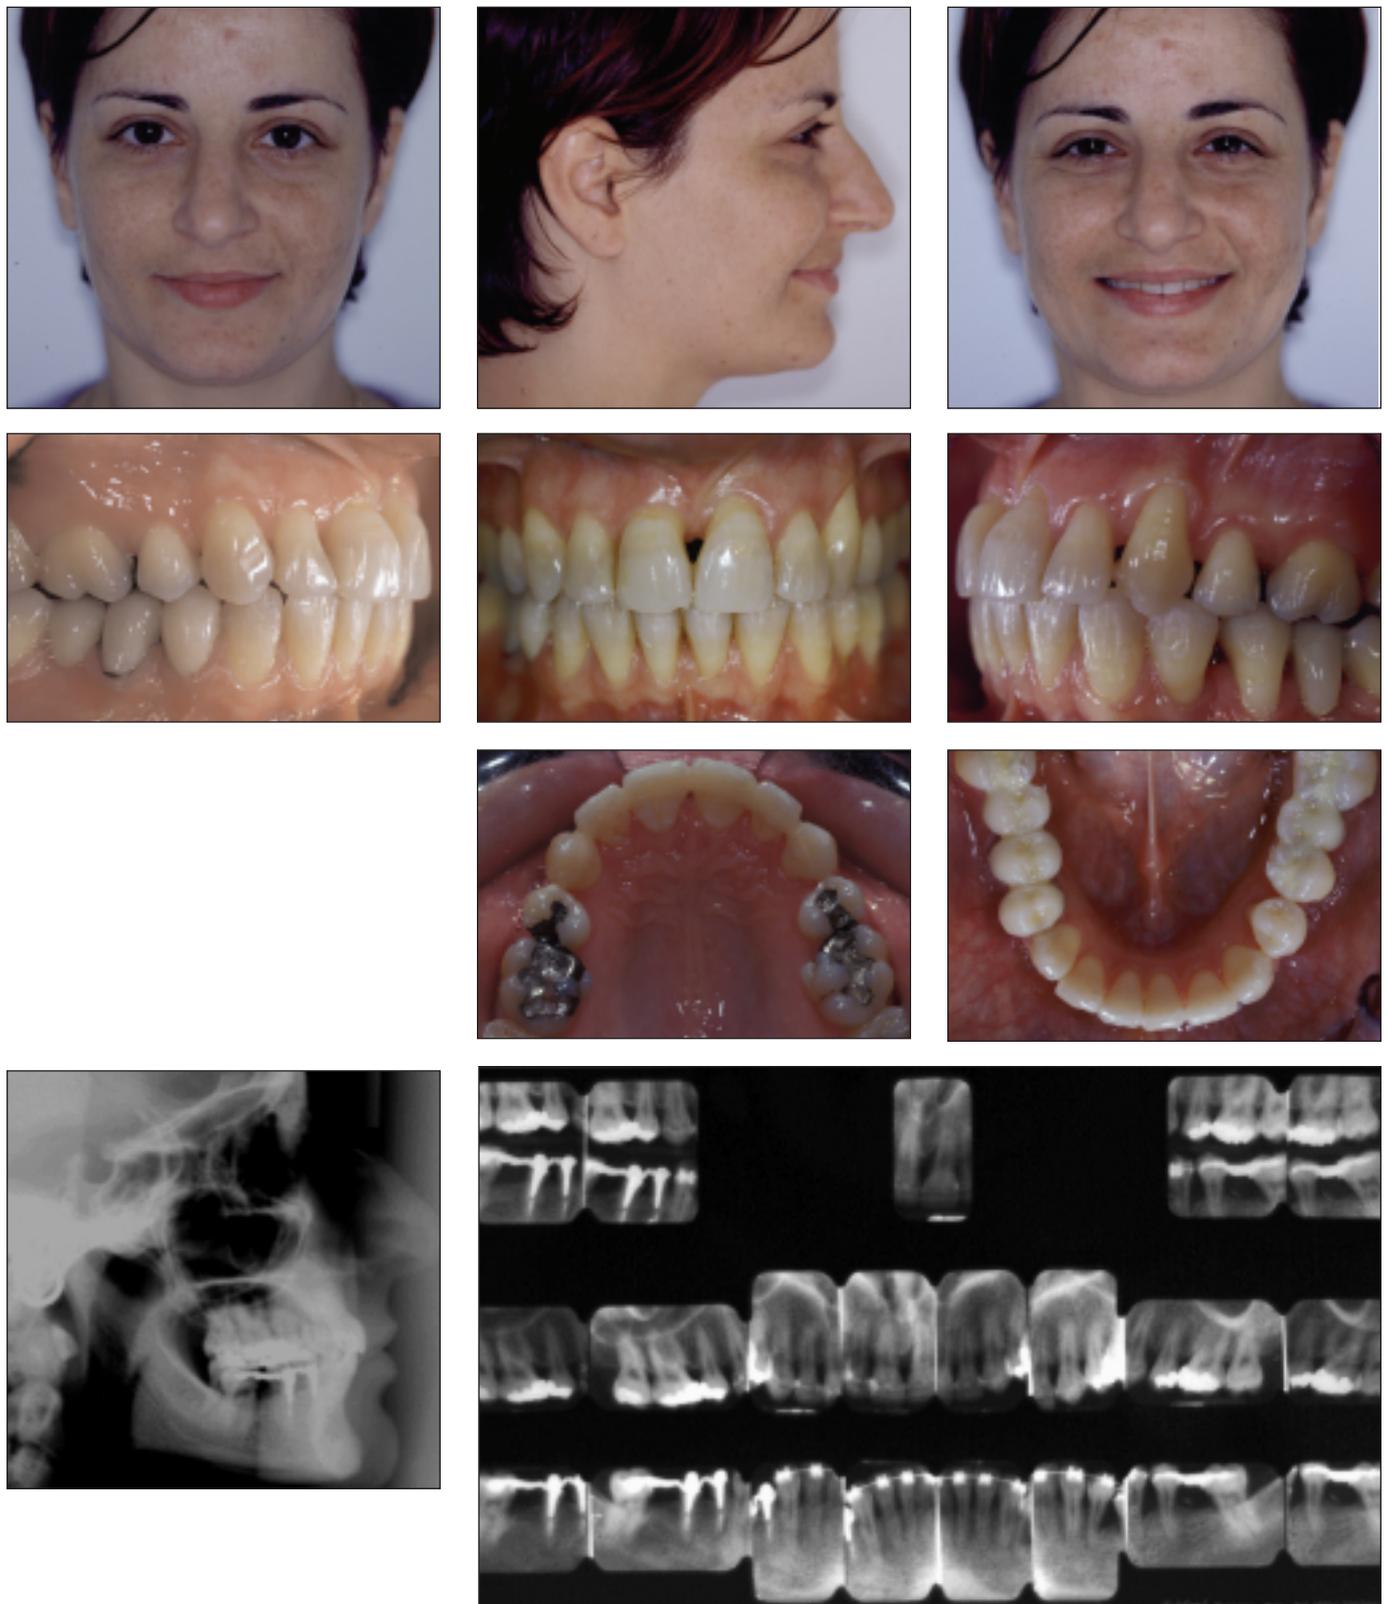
Posttreatment records and radiographs.
